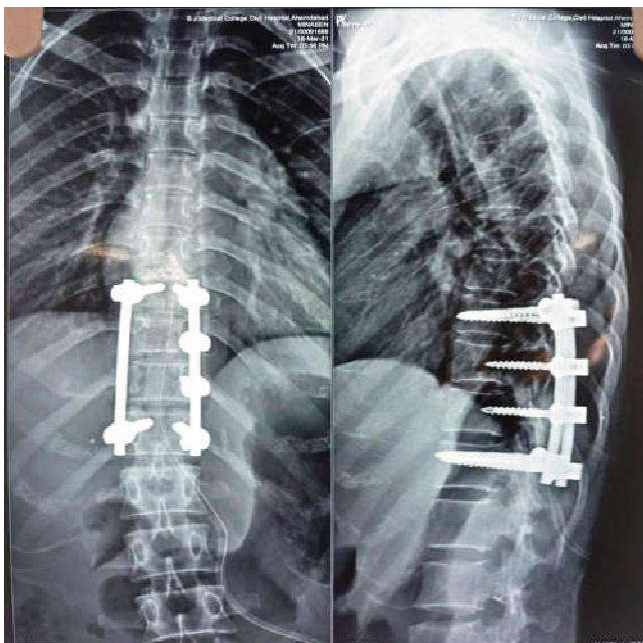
Showing postoperative x-ray with posterior stabilization with pedicle screw and decompression and excision was done
